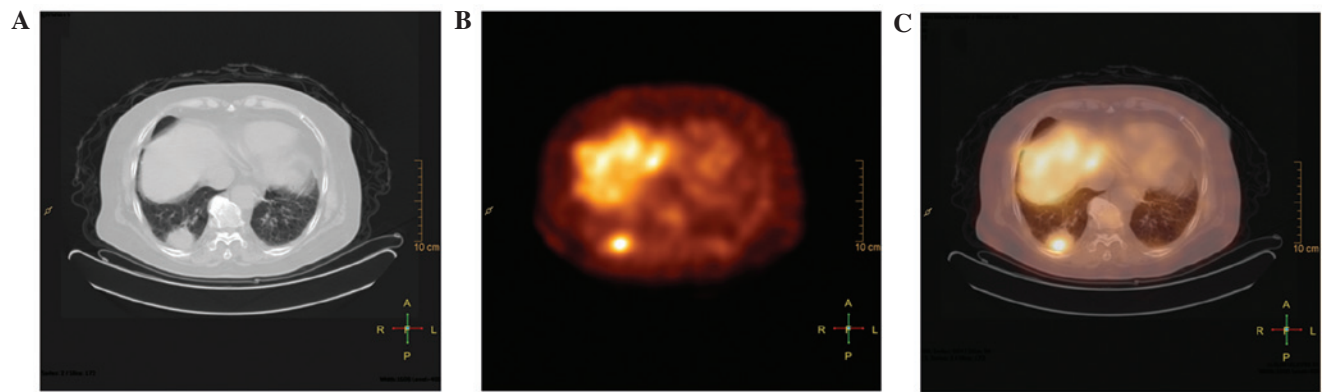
True-positive results for ^{99m}Tc-3P₄-RGD₂ SPECT and SPECT/CT scans, in contrast to a false-positive result for CT. (A) CT, (B) SPECT and (C) CT/SPECT fusion images of a 68 year-old man (patient no. 16) with a 2.7-cm adenocarcinoma and focal uptake of ^{99m}Tc-3P₄-RGD₂ at the inferior lobe of the right lung (tumor to non-tumor localization ratio, 2.38). ^{99m}Tc-3P₄-RGD₂, technetium-99m-(polyethylene glycol-4)₃-(Arg-Gly-Asp)₂; SPECT, single-photon emission computed tomography; CT, computed tomography.
